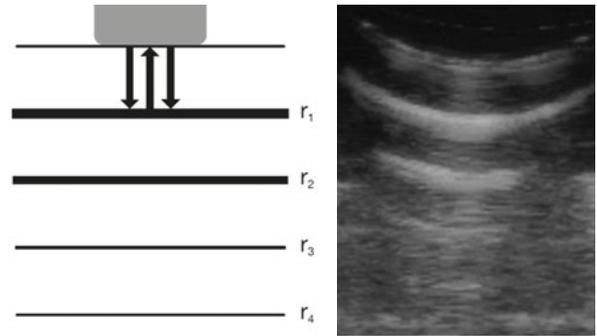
Reverberation echoes: (L) The sound beam travels between probe and strong reflector r_1 . Artefact images r_2 , r_3 , etc. are falsely generated. (R) How this appears in an ultrasound.
